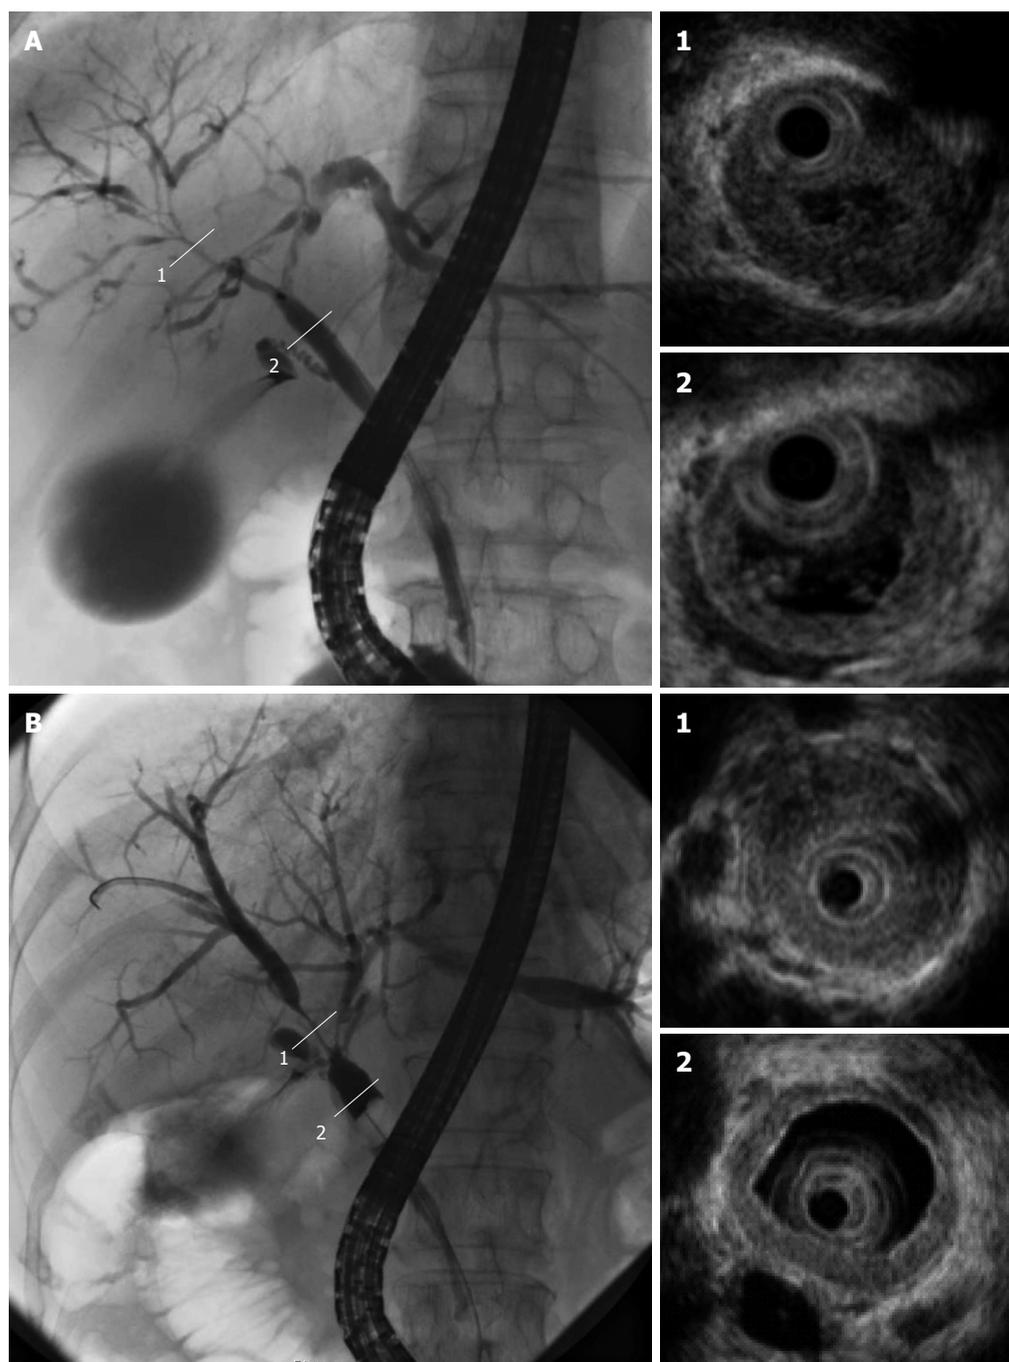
Cholangiogram displaying stenosis in the intrahepatic ducts (A-1) and hilar hepatic lesions (B-1); intraductal ultrasonography revealing bile duct wall thickening in areas with stenosis (1) and without (2).
